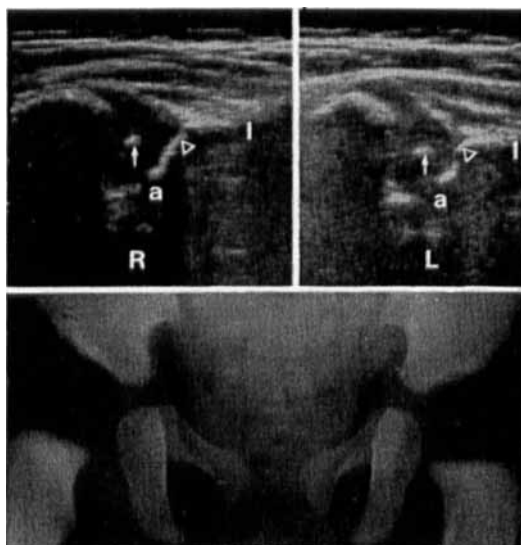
Ultrasound pictures and radiograph of dysplasia of the right hip (R) in a girl 5 months of age. The acetabular index is increased and there is a bony defect of the lateral acetabular rim. I os ilium; other labels as in Fig. 2. The left hip (L) is normal.
